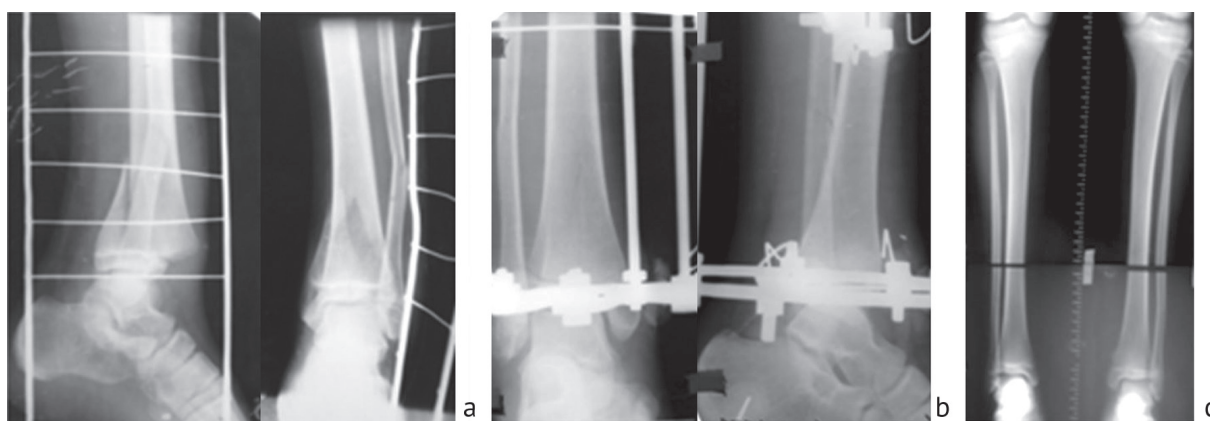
Closed fracture of the distal epimetaphysis of the tibia (SH II). Radiographs taken in two projections: a before the operation; b after Ilizarov osteosynthesis; c after dismantling the Ilizarov apparatus
